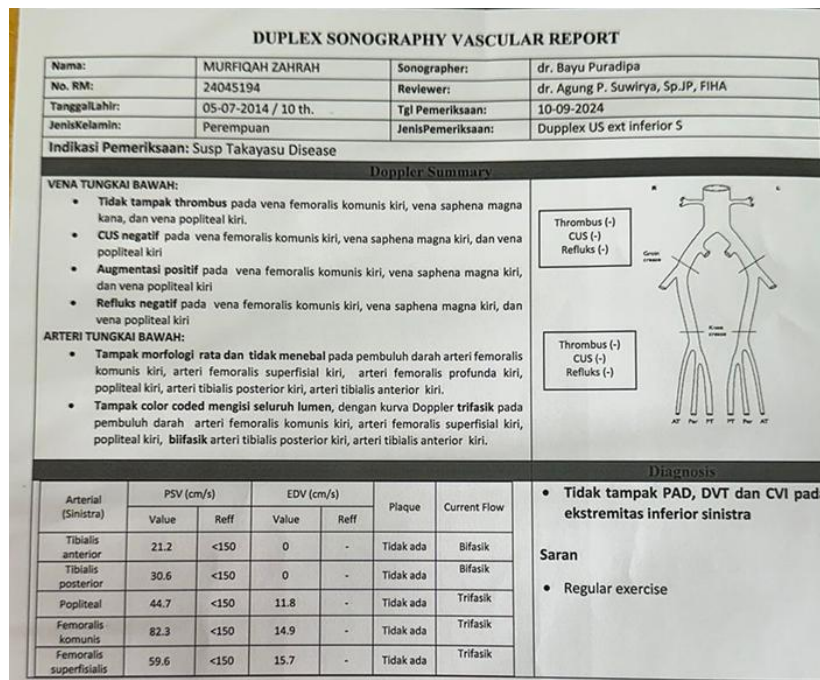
Results of Duplex Sonography Vascular Left Inferior Extremity Examination
